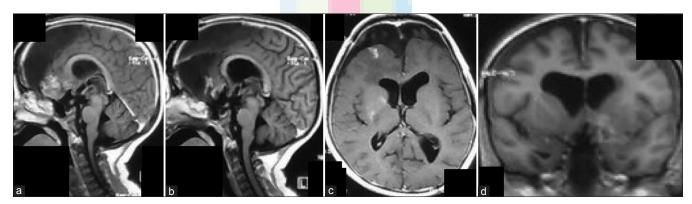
Patient 1: Postoperative MRI T1 weighted image (a and b: sagittal; c: axial; d: coronal) showing minimal residual tumour
